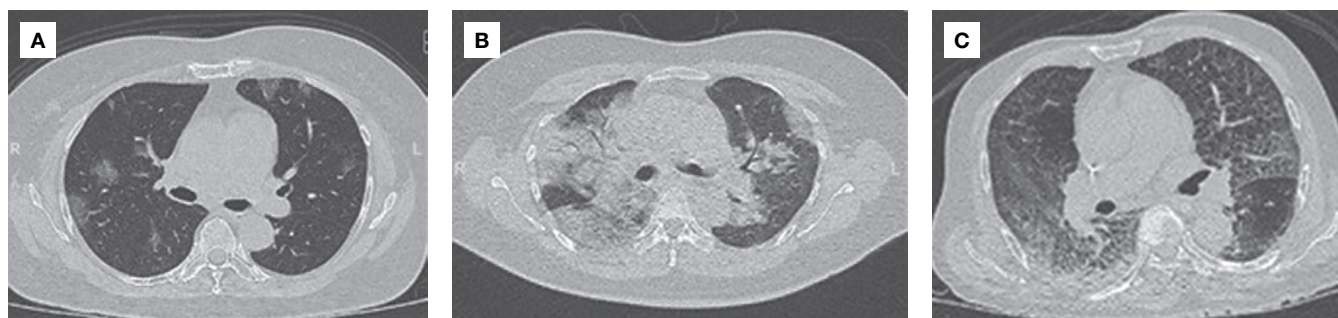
(A) Plain chest CT showing bilateral peripheral lower lobe ground glass opacities. (B) Plain chest CT showing bilateral diffuse ground glass opacities and consolidation. (C) Plain chest CT showing bilateral patchy consolidation and crazy paving pattern.
